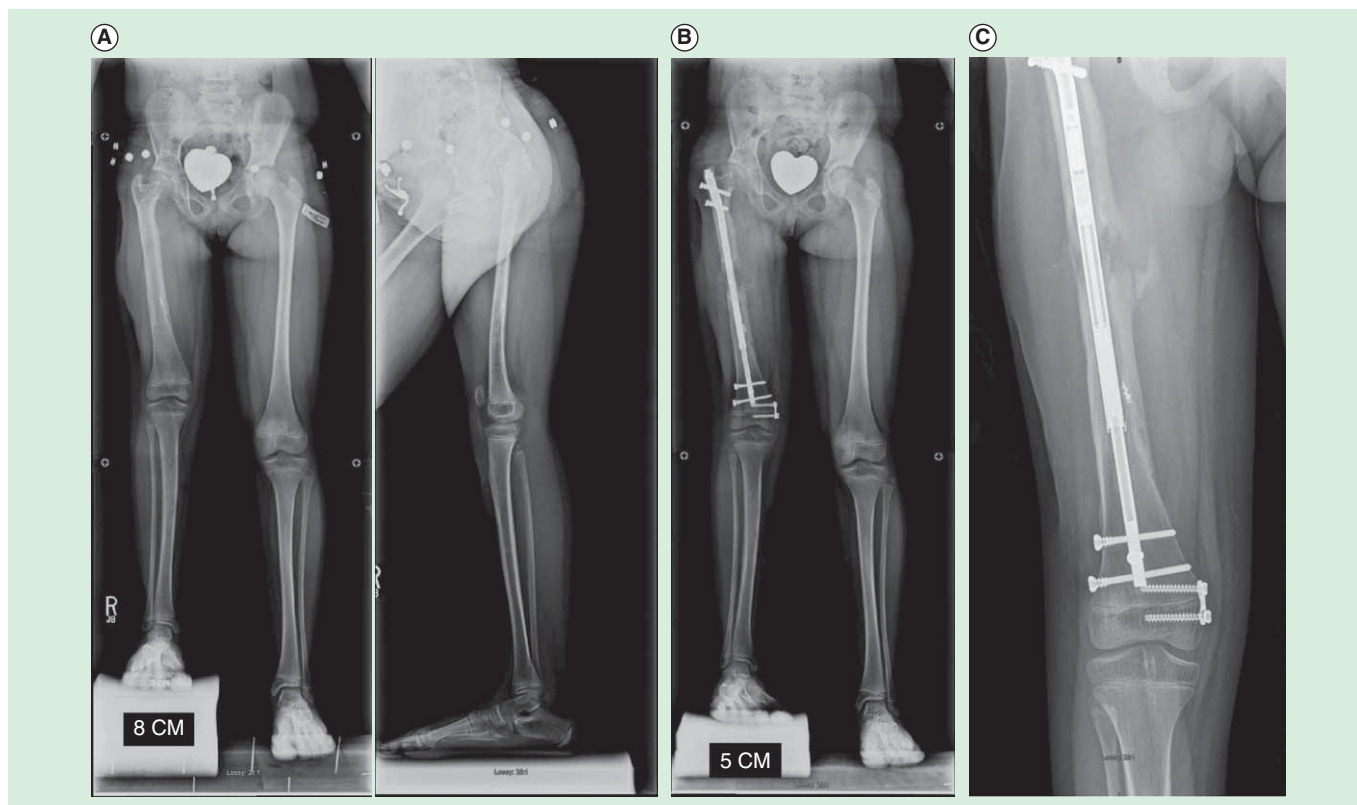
Eight year old girl with congenital femoral deficiency. (A) Preoperative AP and lateral radiographs. She had been previously treated by a superhip-superknee surgery and has also successfully undergone one external fixator lengthening at age 4. Her leg length discrepancy was 7 cms. (B) AP radiograph after 5cms of lengthening by Precice2 8.5mm x 245mm, trochanteric entry femoral nail. Her genu valgum was treated at the same time by a hemi-epiphysiodesis plate. (C) This AP radiograph during the consolidation phase shows the distraction gap filling in with bone one month after stopping distraction.
